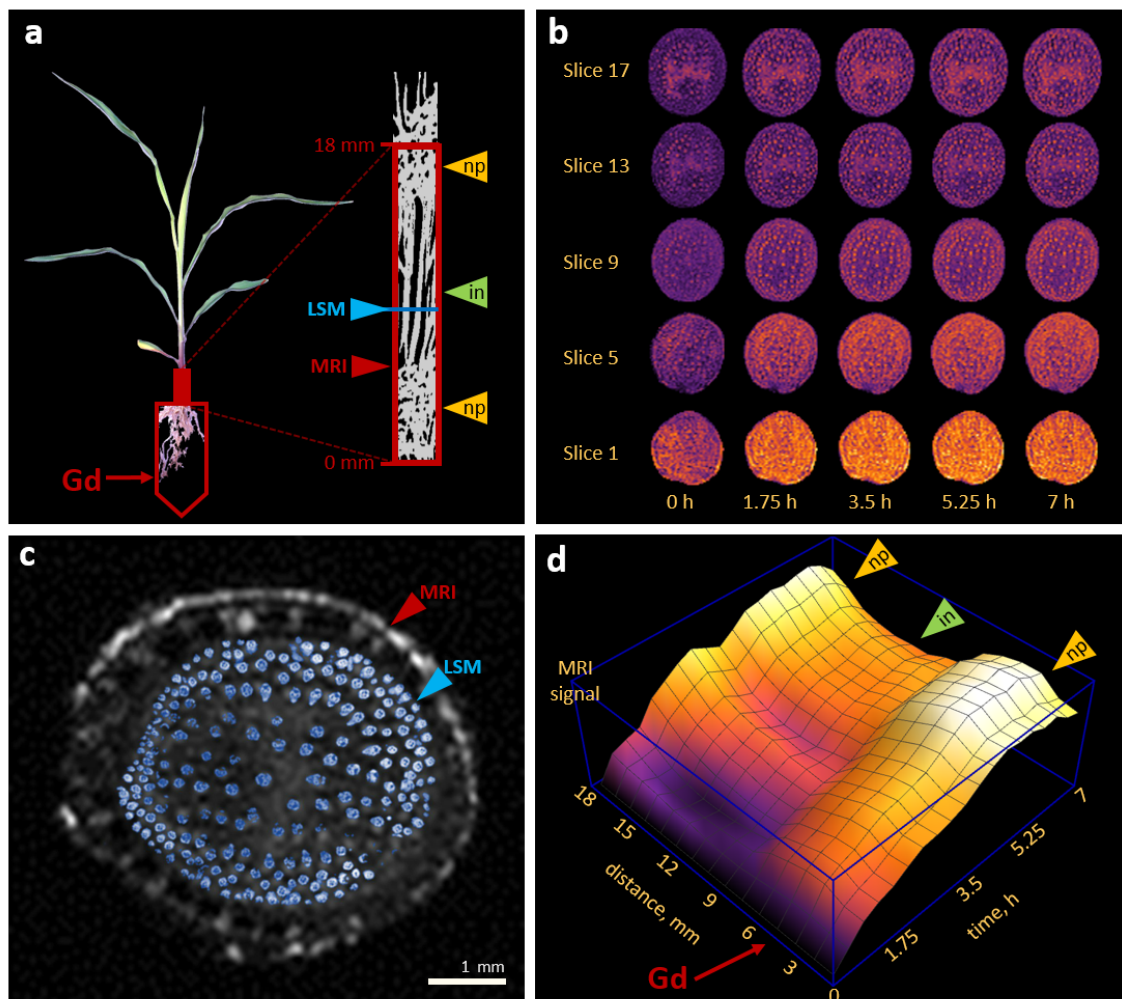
Contrast-enhanced MRI study of gadolinium chelate distributing inside nodal plexus (np) and internodes (in) of the maize stem. (a) The MRI-studied area marked by red arrow was located at the bottom of the maize stem directly from the root/shoot nodal plexus (np) and 18 mm higher. The location of the internode (in) section for high-resolution LSM-imaging is marked with a blue arrow. (b) Temporal series of MRI slices. (c) Matching between internodal vascular bundles in the MRI slice and in the high-resolution LSM-image. (d) Spatial-time distribution for the MRI signal reflecting Gd penetration into maize stem xylem vascular system. The red arrow indicates the roots/stem connection region, which can be interpreted as a source of gadolinium chelate.
